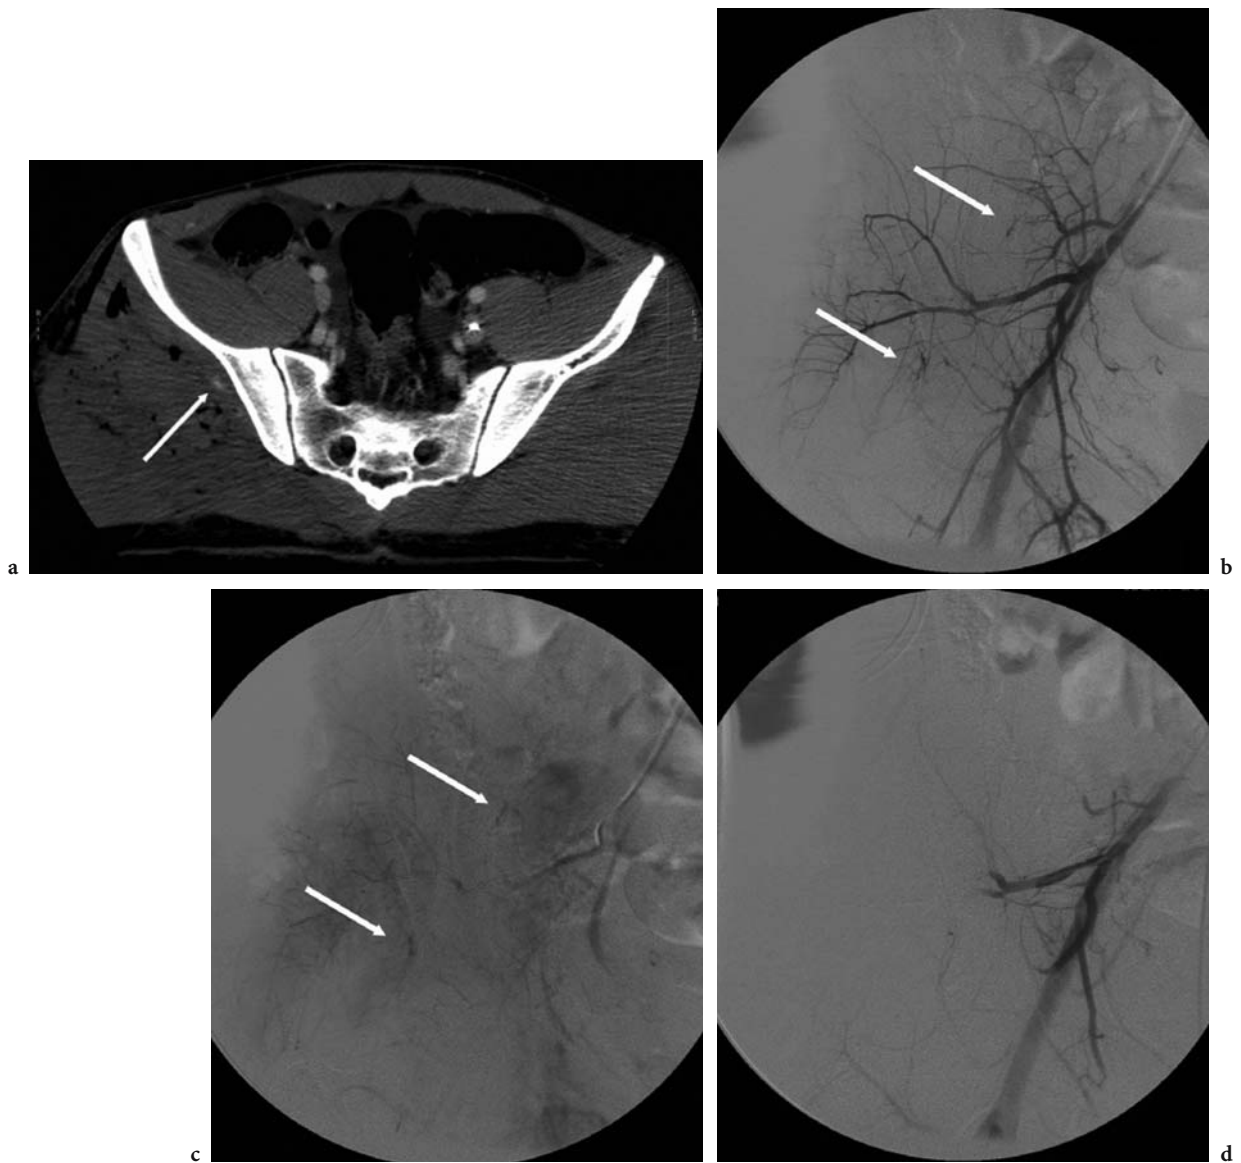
Thirty-one-year-old male involved in a motorcycle accident collision and suffered multiple injuries including right femur fracture and a laceration of the right buttock. The patient was hypotensive and no definite pelvic fractures were seen on plain film. a Pelvic CT demonstrated active extravasation of contrast from a right superior gluteal artery branch and an expanding right side. b Arterial phase angiogram of the right internal iliac demonstrates two areas of extravasation. c Venous phase angiogram shows retention of contrast in the suspected areas. d Post-Gelfoam embolization angiogram shows truncation of the distal branches of the superior gluteal artery.
